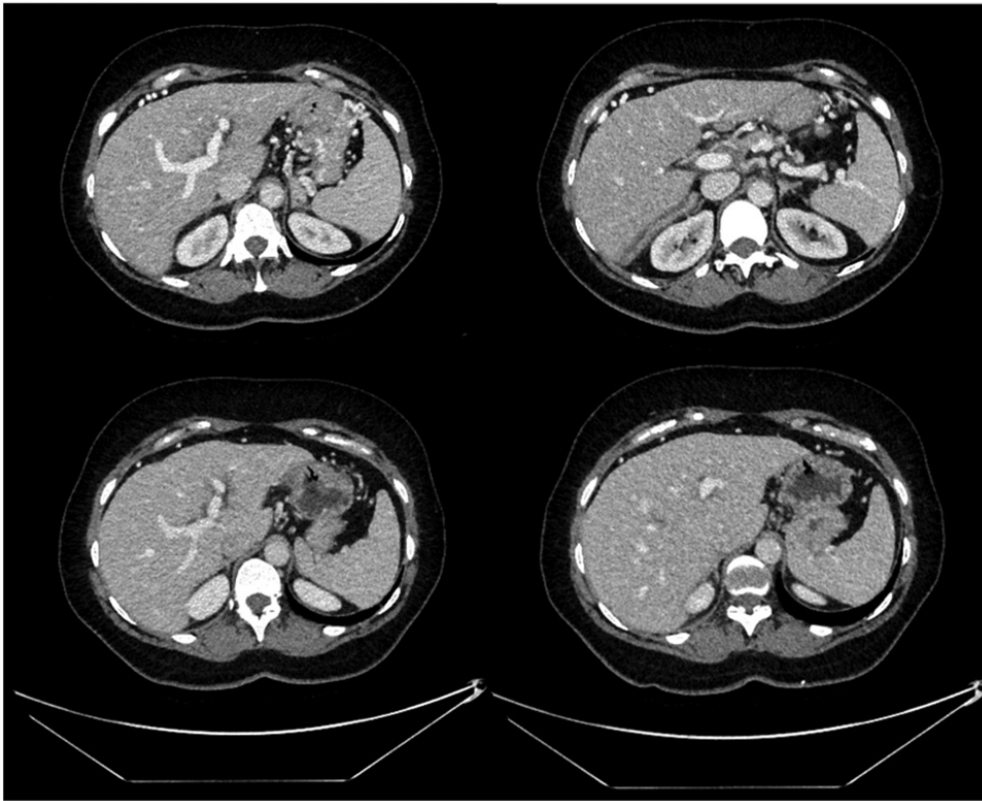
Sustained radiological disappearance of liver metastases during systemic therapy (2019). Top row: Interval contrast-enhanced CT performed in June 2019, with axial images (left) and coronal reconstructions (right), demonstrating no radiologically identifiable liver lesions. Bottom row: Interval contrast-enhanced CT performed in December 2019, with axial images (left) and coronal reconstructions (right), confirming persistent absence of radiologically detectable liver metastases. At this stage, the patient had completed 19 cycles of FOLFIRINOX chemotherapy, with sustained hepatic response.
